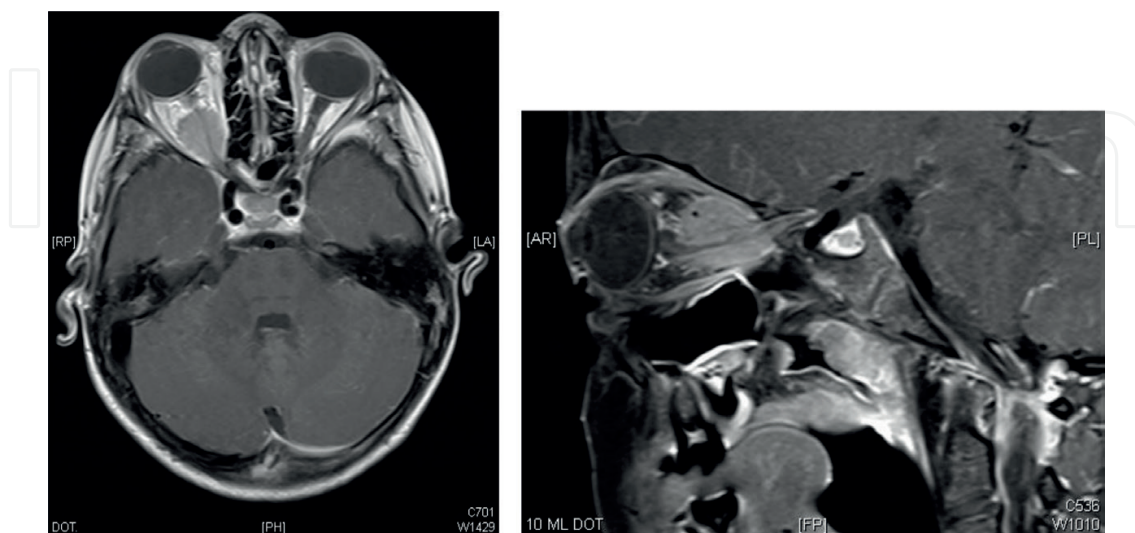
Optic nerve sheath meningioma. T1-weighted MRI showing right oval orbital space occupying lesion encasing the mid and posterior right optic nerve.
